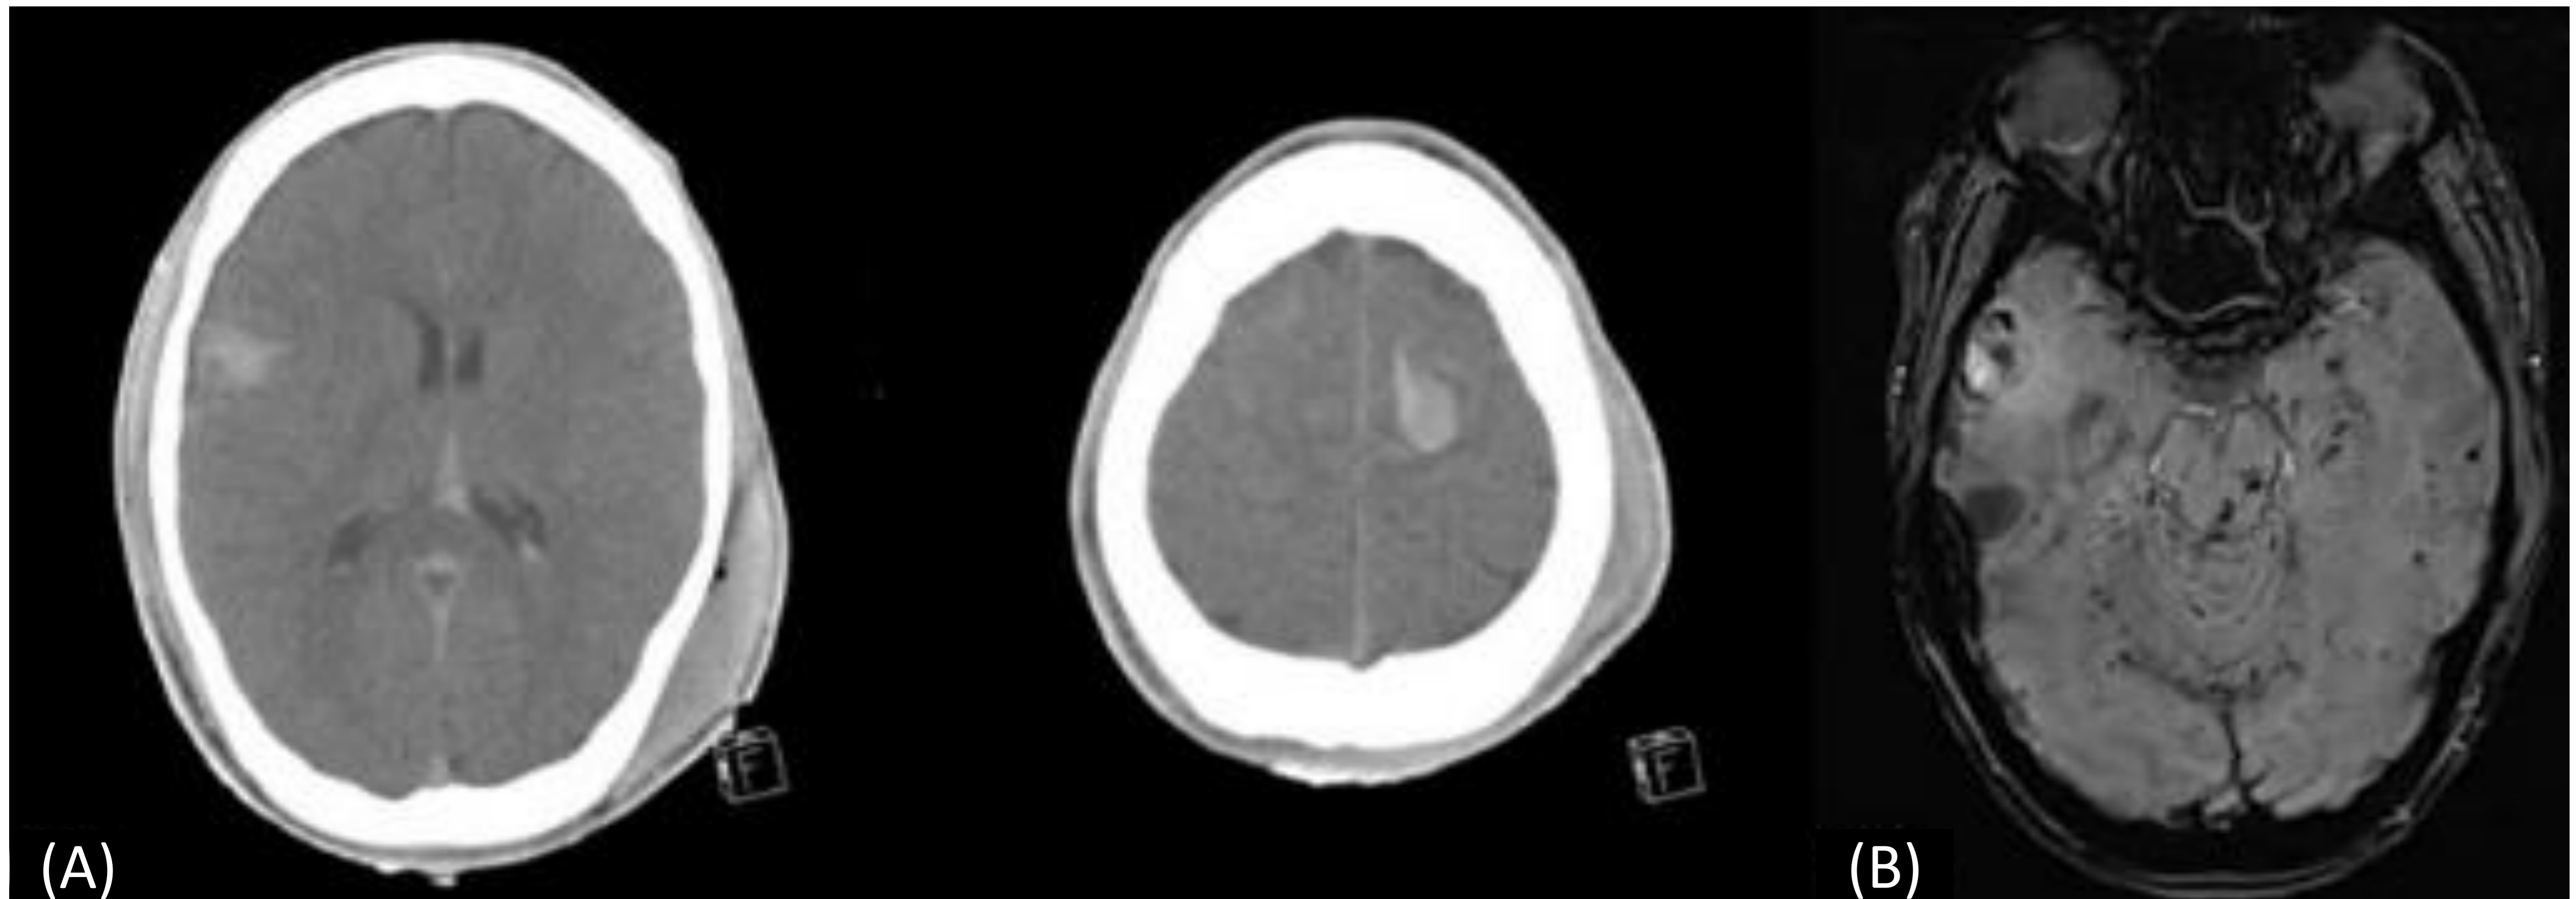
(A) Initial brain CT showing traumatic subarachnoid hemorrhage, (B) Susceptibility-weighted MRI showing diffuse microbleeds, consistent with diffuse axonal injury
